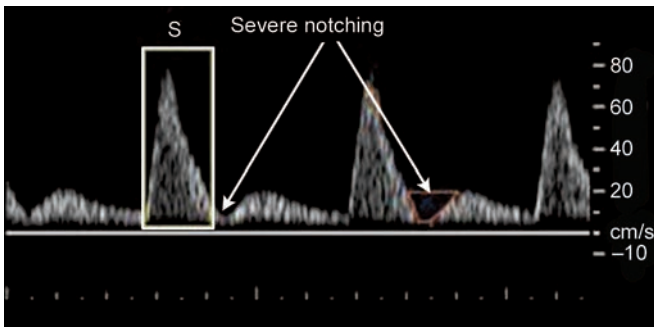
Diastolic notching on Doppler analysis
